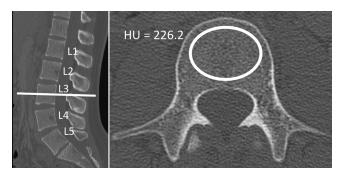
CT attenuation was measured by first locating the midvertebral body in the sagittal plane. Axial click-and-drag elliptical ROI were manually placed to be as large as possible while safely avoiding the cortical shell and vertebrobasilar complex. The picture archiving software reported the average CT attenuation of the ROI in Hounsfield units (HU)
